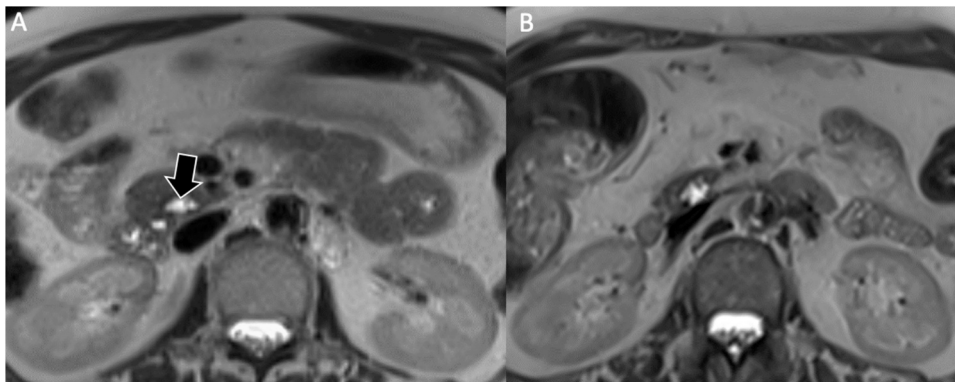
51-year-old woman with IPMN stable in size at 4-year-follow-up. T2-weighted non-fat sat images acquired in 2018 (A) and 2022 (B), show a BD-IPMN (arrow) that remains stable in size over time.
